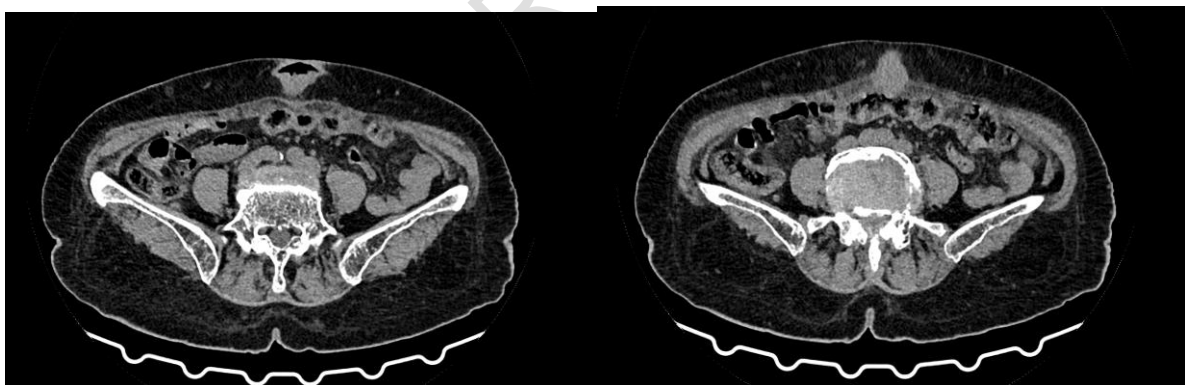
Axial Contrast Enhanced CT-scan showing the SMJN (white arrow).
